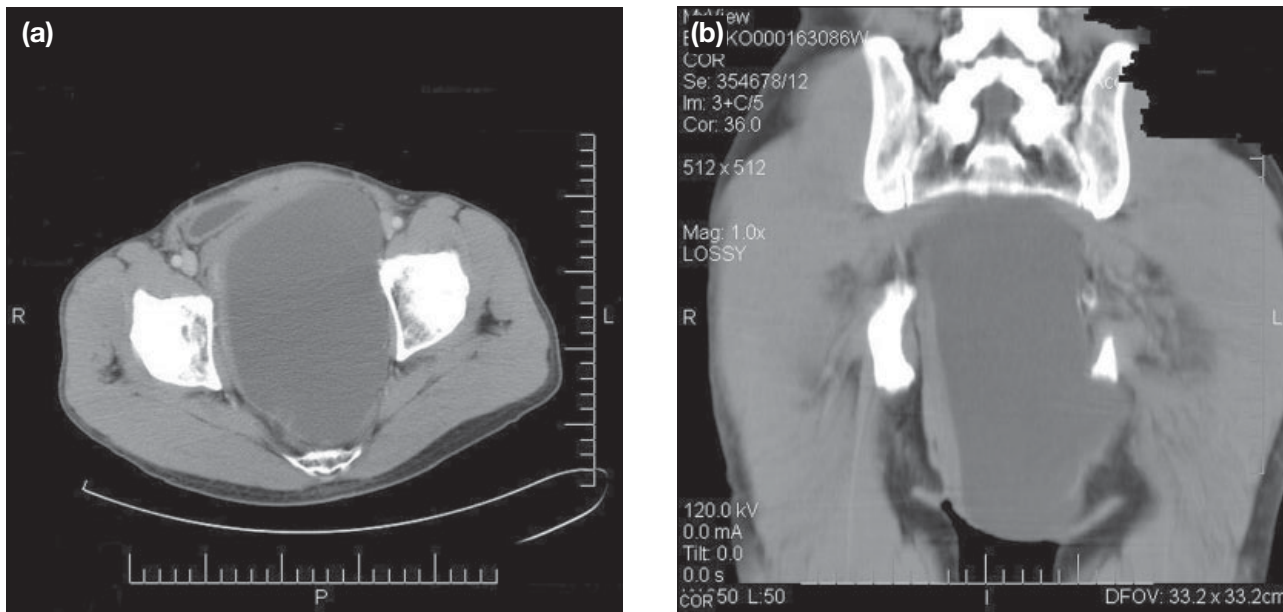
Postcontrast computed tomograms: (a) axial and (b) coronal reconstruction showing a well-defined cystic lesion.
